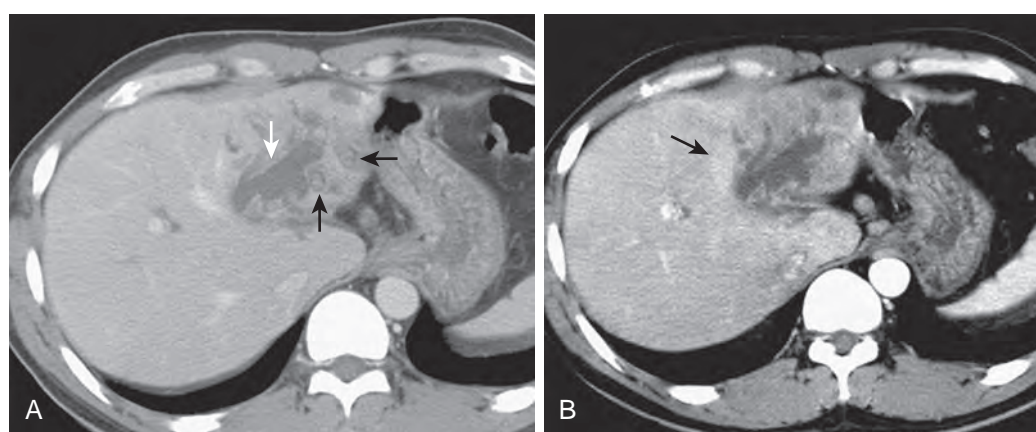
Recurrent pyogenic cholangitis with abscess. A. CT scan obtained during portal venous phase demonstrates stones in dilated intrahepatic ducts of left lateral segment (black arrows). There is an abscess with fluid attenuation in the liver parenchyma (white arrow). B. Scan obtained during the arterial phase demonstrates increased contrast enhancement around the abscess (arrow) related to hyperemia (transient hepatic attenuation difference).
